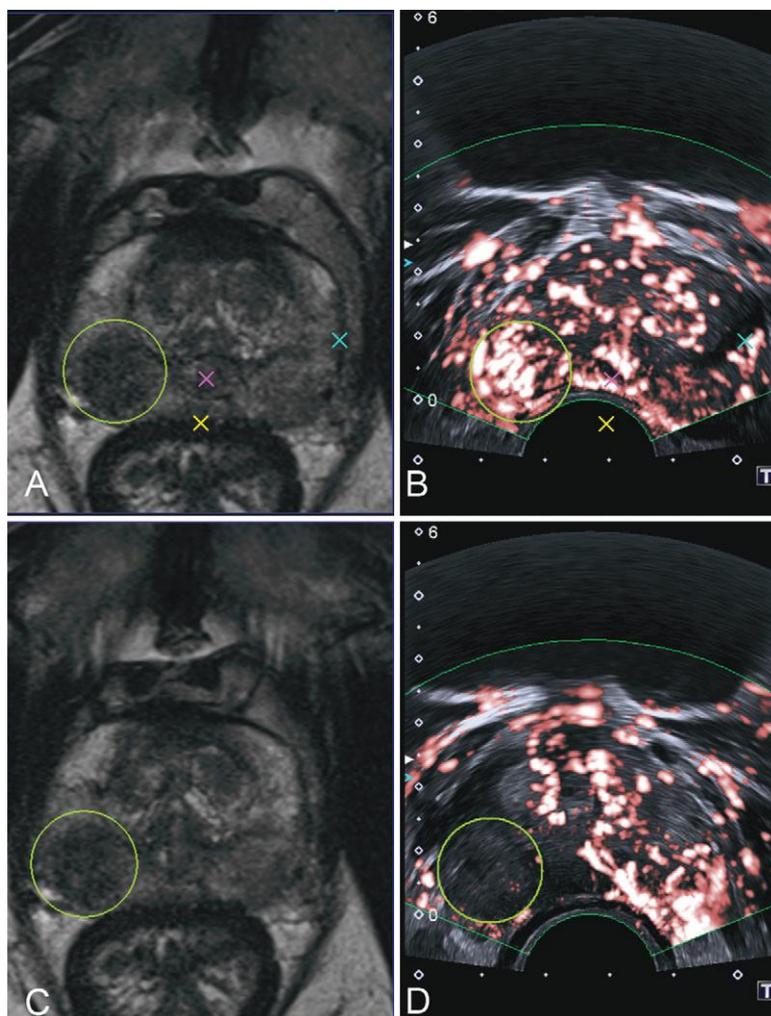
Images in a 63-year-old man with Gleason score 3 + 4 prostate cancer. Representative images of contrast-enhanced US imaging by using MRI–transrectal US fusion technique before and 1 day after irreversible electroporation (IRE). Tumor is marked with spherical volume of interest (green circle). Three small Xs are anatomic landmarks used for image fusion indicating urethra, dorsal boundary, and lateral boundary of gland. A, B, Preoperative contrast-enhanced US images show focal area of hyperperfusion corresponding to tumor in right peripheral zone. C, D, Postoperative contrast-enhanced US images 1 day after IRE show large perfusion defect corresponding to ablation zone. At 6-month follow-up, participant showed prostate-specific antigen level reduction of 70%. Both multiparametric MRI and targeted biopsy confirmed absence of residual tumor.
